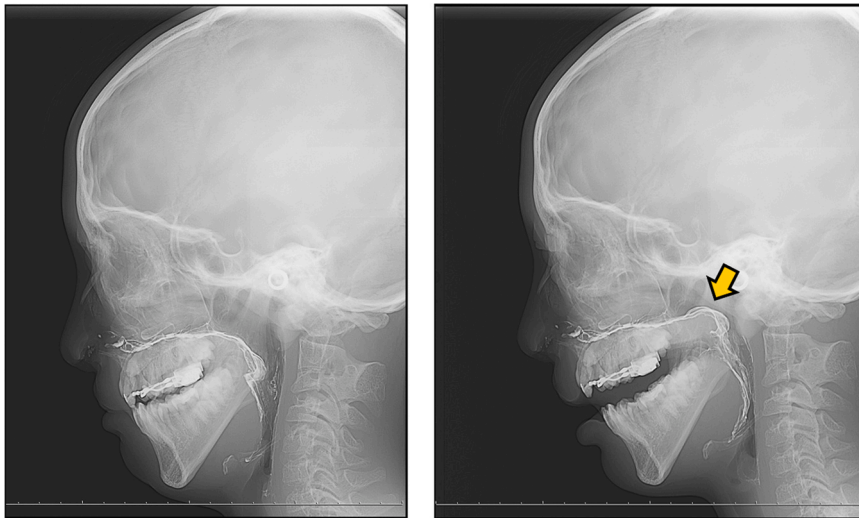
Lateral X-ray images before injection. Lateral X-rays were used before injection to check where the levator veli palatini muscle would be elevated during vowel pronunciation, resulting in restenosis of the pharynx. A contrast medium applied through the nasal cavity made the nasal side of the levator veli palatini muscle clear.
